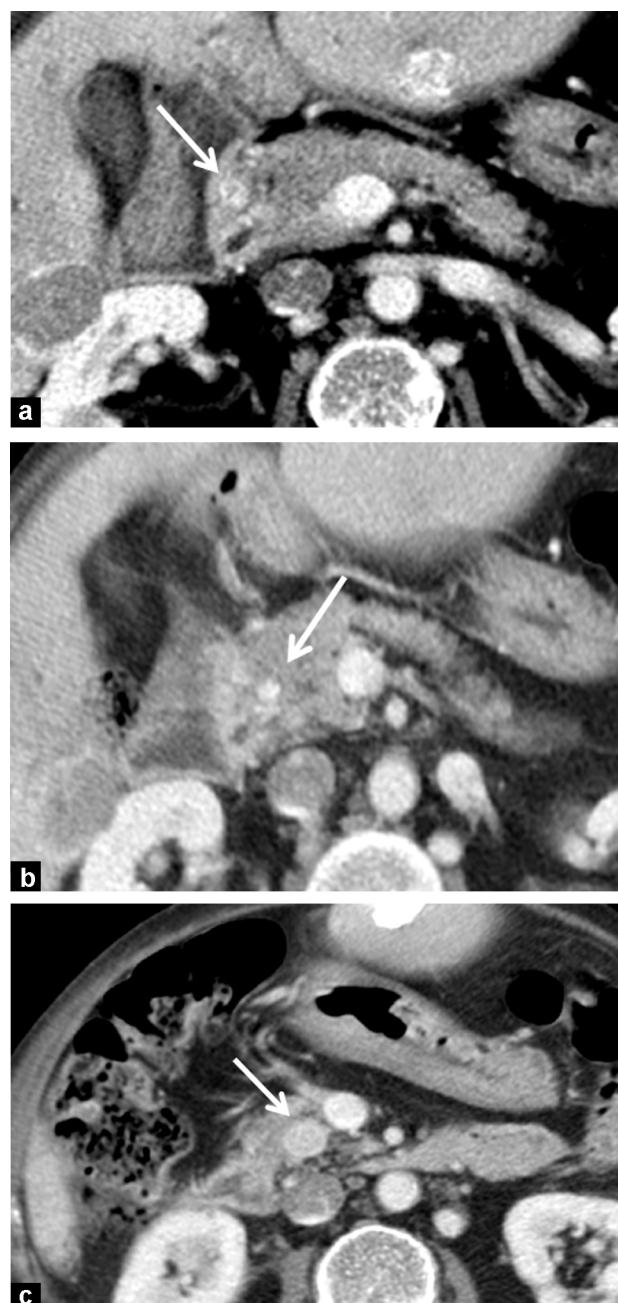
Multiple gastrinoma associated with a MEN1. CT images obtained in the transverse plane at different levels of the pancreatic gland during the arterial phase (a–c) show 3 hypervascular tumors located in the gastrinoma triangle defined by the confluence of the cystic and common bile duct superiorly, the second and third portions of the duodenum inferiorly, and the neck and body of the pancreas medially.
